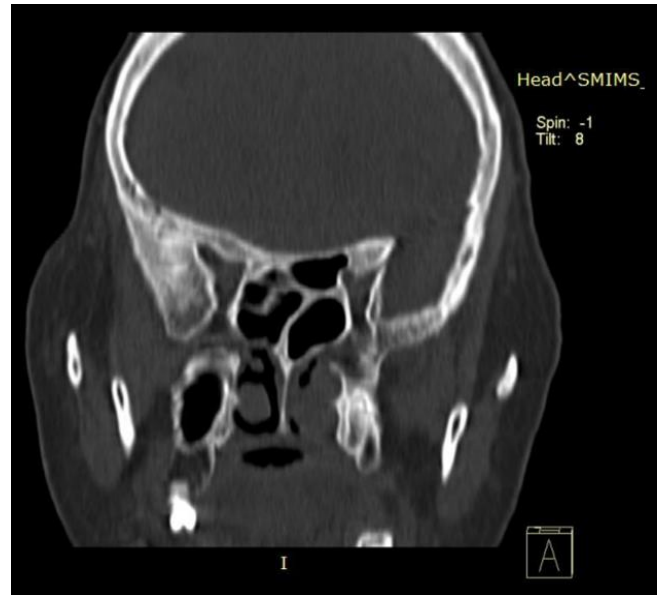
coronal section of CT PNS shows onodi cell.
